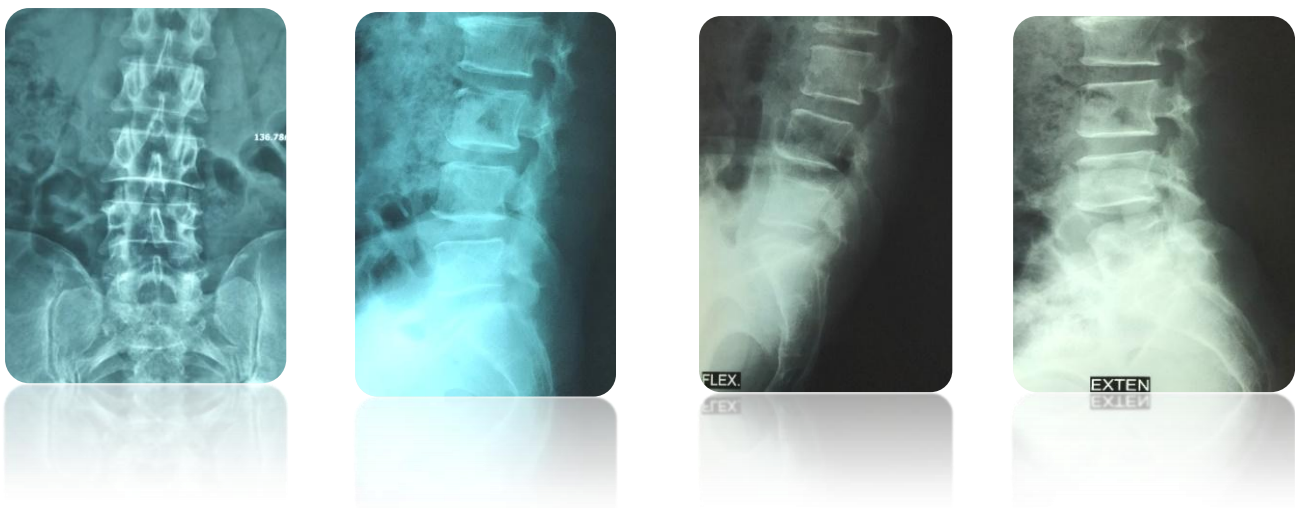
Pre-operative X-ray of lumbosacral spine (A/P, Lateral view and dynamic xray).
